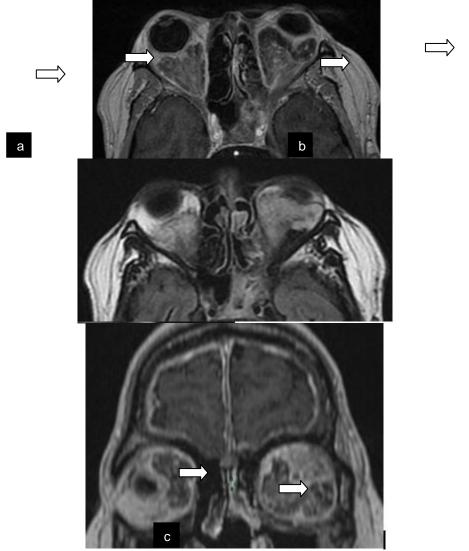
enhanced CT-scan showing : 02 intraconic and retrocular massessurronding the optic nerve and repressing the oculomotormusclesthatisheterogenouslyenhanced
